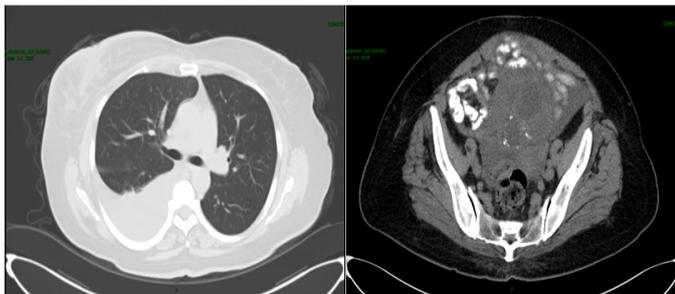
Thoracic CT scan with pleural effusion. Abdominal CT scan identifying a right ovarian tumor 10×13×7.67 cm above the median line of the hypogastrium, with mixed density and small calcifications.
